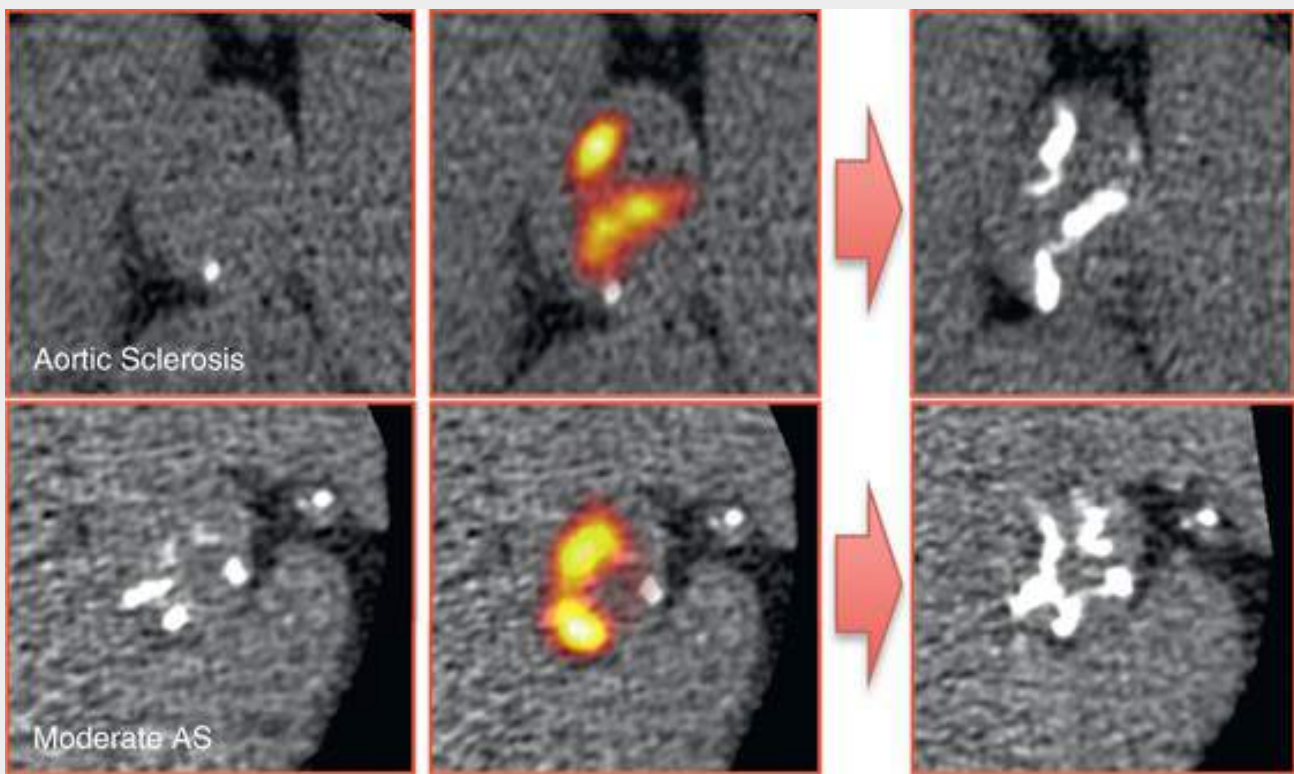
Valvular ^{18}F -fluoride uptake predicts the progression of calcification in aortic stenosis (AS). Two patients with calcific aortic valve disease. Left, Baseline computed tomography (CT) images. Middle, Fused positron emission tomography (PET)/CT images showing increased ^{18}F -fluoride valvular uptake (red/yellow areas). Right, Repeat CT scans after 2 years with new areas of macroscopic calcium (white areas) in a similar distribution to that of baseline PET uptake. (Jenkins WS, Vesey AT, Shah AS, et al. Valvular (18)F-fluoride and (18)F-fluorodeoxyglucose uptake predict disease progression and clinical outcome in patients with aortic stenosis. *J Am Coll Cardiol* 2015;66:1200-1.)
